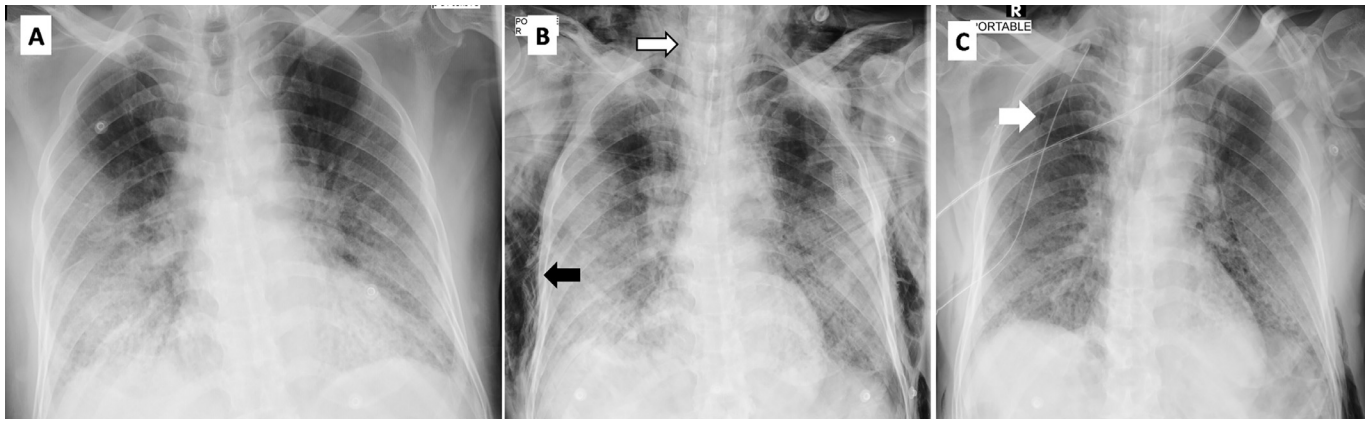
Serial chest x-rays in a patient with covid-19 infection demonstrating clinical course of mediastinal emphysema.
